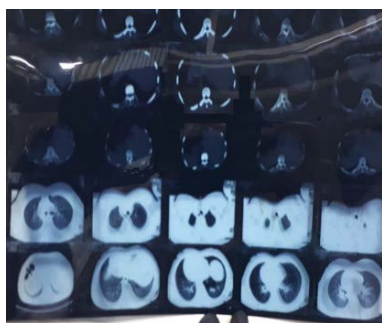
CT scan of chest, no significant changes apart from mild left side pleural effusion.
